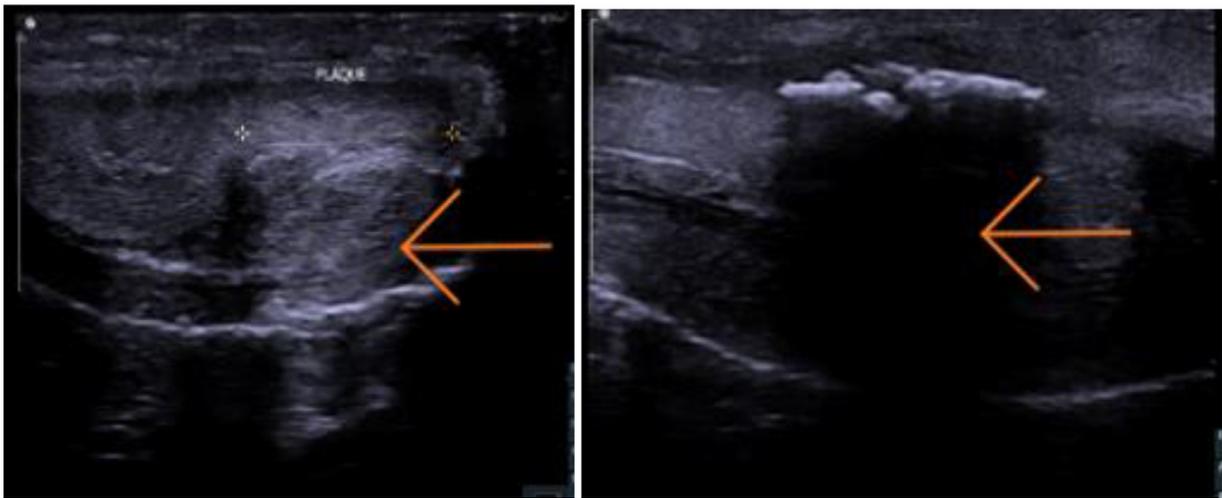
Representative image of Ultrasound detected Peyronie's disease plaques in 2 patients. Left, a noncalcified plaque without acoustic shadowing. Right, a calcified plaque with posterior acoustic shadowing. (Color version available online.)
